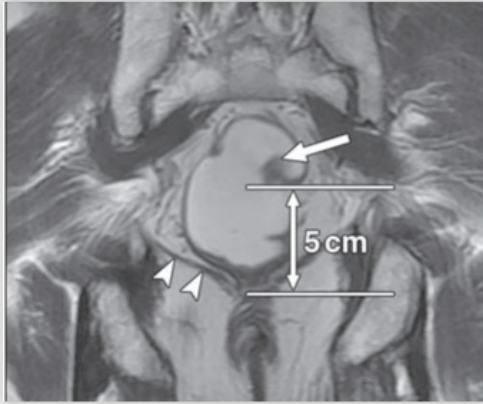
57-year-old man with T1 well differentiated rectal adenocarcinoma (arrow). Coronal T2-weighted MR image shows distance from lower margin of rectal cancer to upper margin of external sphincter, where levator ani muscle (arrowheads) attached to rectum, was 5 cm (double arrow). Patient underwent sphincter-sparing resection of rectum.
